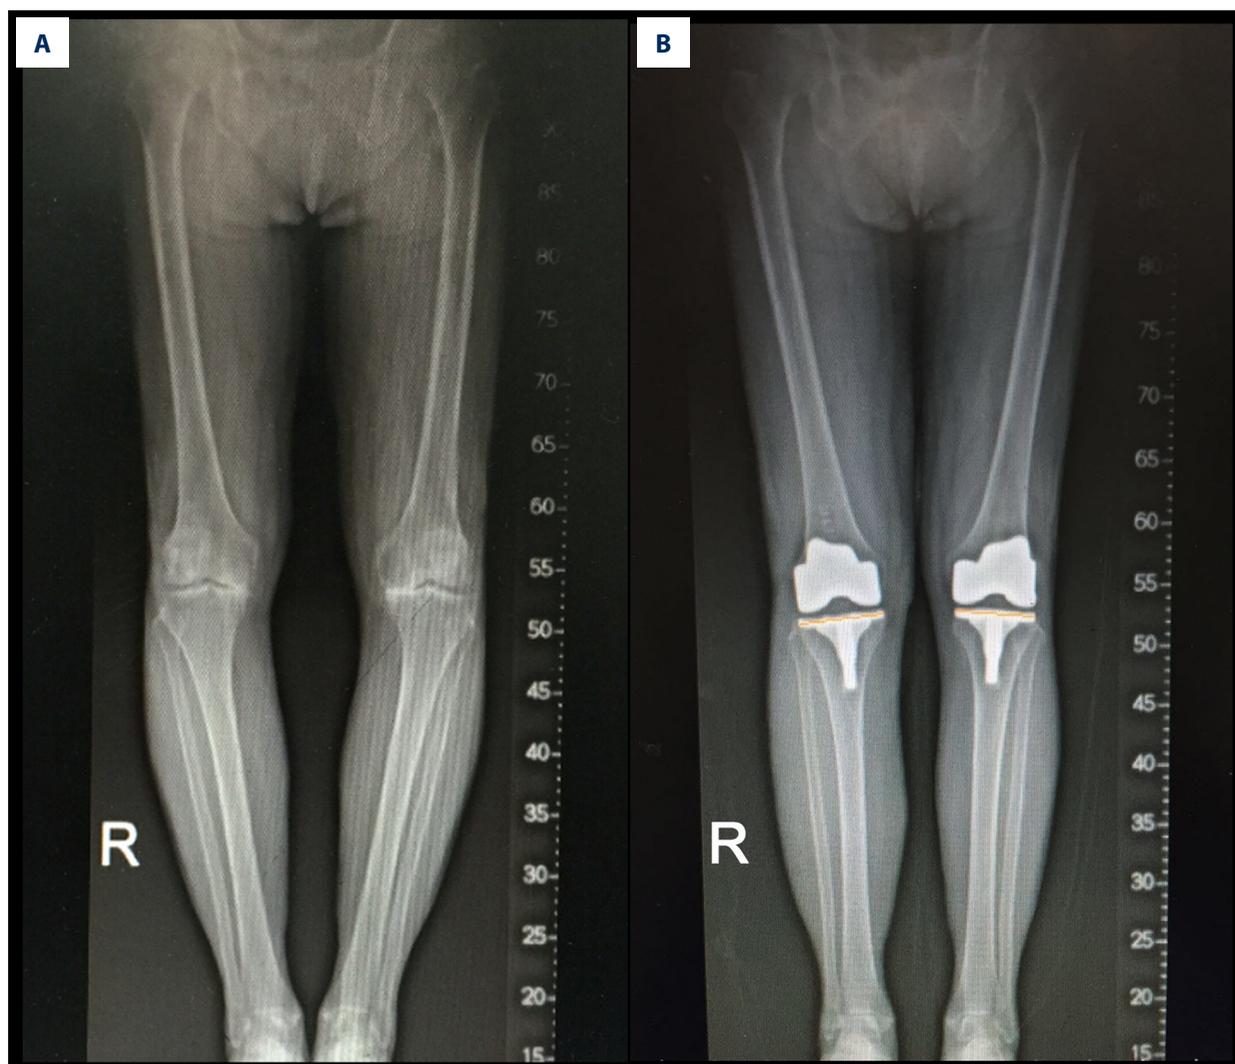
Standardized preoperative and postoperative weight-bearing anteroposterior radiograph of the whole lower extremities are presented respectively in a same patient. (A) Bilateral varus knees before arthroplasty. The patient's left knee was treated with reduction osteotomy and the right knee was treated with extensive medial soft tissue release. (B) The left tibial prosthesis is one size smaller than the right tibial prosthesis due to resection of tibial bone.
